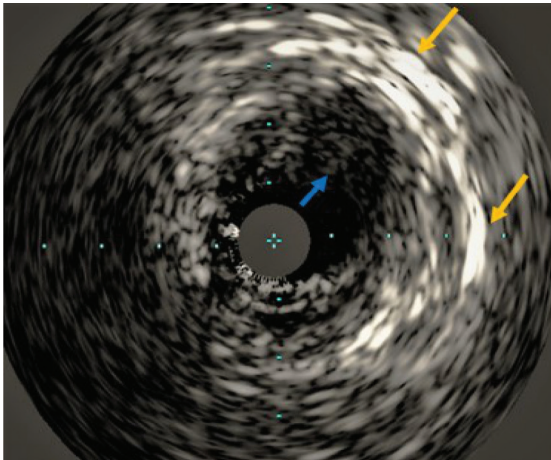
Pre Shockwave intravascular lithotripsy intravascular ultrasound (IVUS) of left internal mammary artery (LIMA) ostia (blue arrow: intraluminal soft tissue plaque; yellow arrows: severe eccentric calcification of arterial wall).
